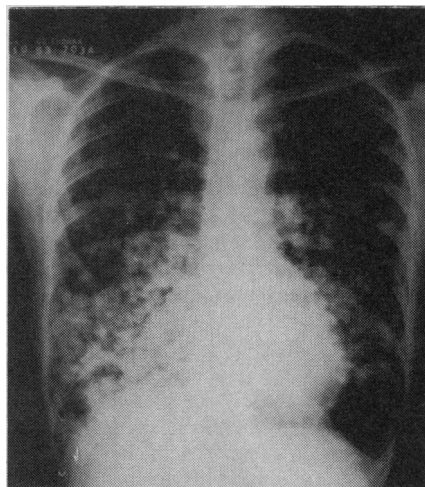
Chest roentgenogram showing nodular opacities in both lungs in 1953.
